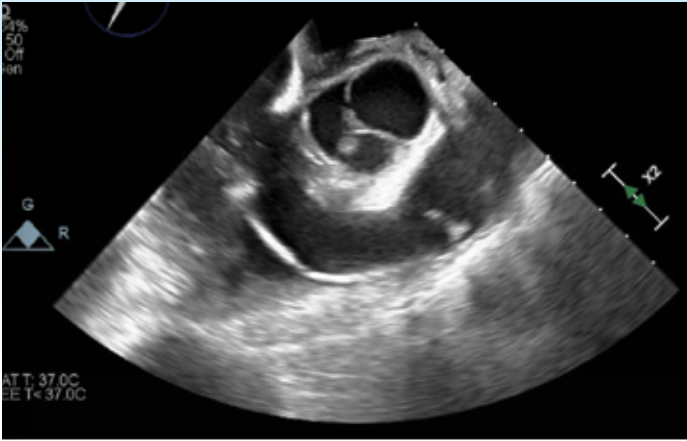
Transesophageal echocardiography post chest closure
